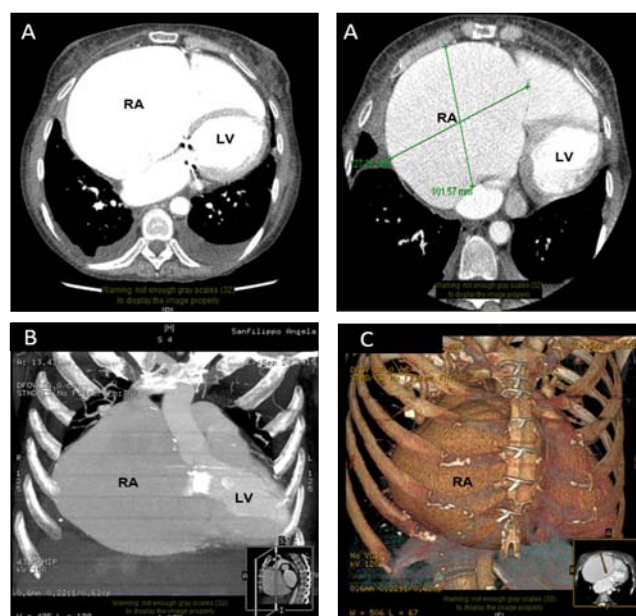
Chest computer tomography images showing giant right atrium and biological valve prosthesis. Axial (a), coronal (b) views and 3D CT reconstruction (c) RA, right atrium; LV, left ventricle.
